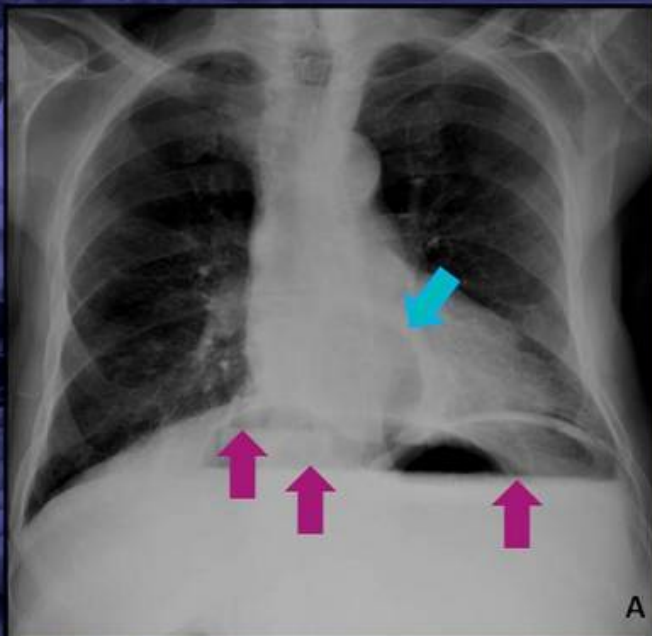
(A) Frontal chest radiograph of a patient with a previously known paraesophageal hiatal hernia demonstrates air-fluid levels in the upper abdomen (pink arrows) and a gas-filled structure in retrocardiac position (blue arrow). (B) and (C) The barium x-rays show torsion of the stomach at the level of the antrum, which herniates along with the duodenal bulb into the thorax, thus confirming the diagnosis of a mesentero-axial gastric volvulus. This type of gastric volvulus is less frequently associated to diaphragmatic defects than organo-axial volvulus.
